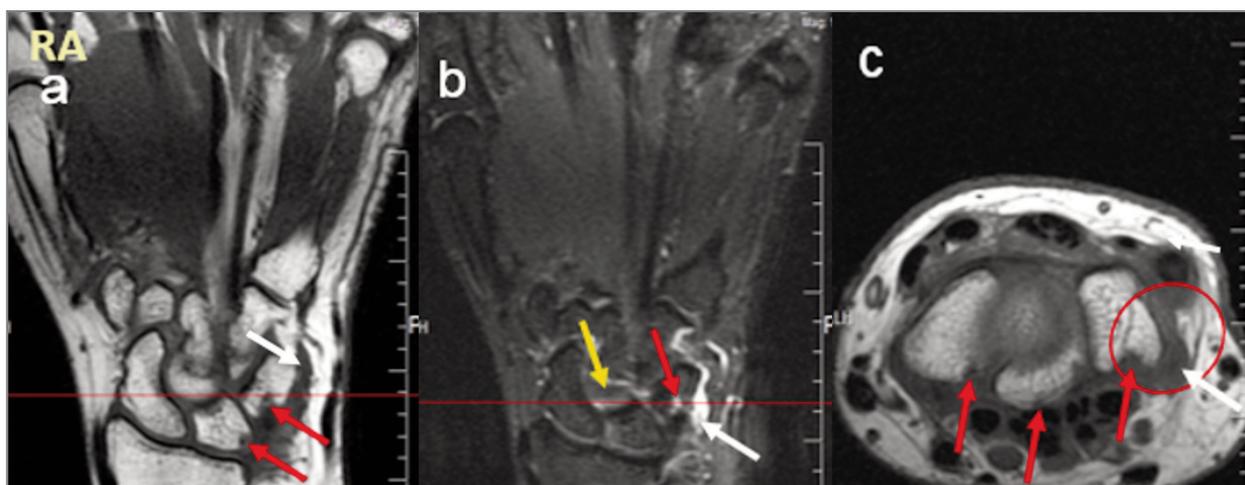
Hand-wrist MRI Coronal T1 and STIR in a rheumatoid arthritis (RA) patient. First Carpal line lesions in a 45 year-old woman. White arrows show synovitis; red arrow shows erosion; yellow arrows show bone marrow edema (osteitis). A) T1 sequence synovitis in triquetrum is seen hypointense (white arrow) and erosions are seen in the triquetrum, lunate and scaphoid bones edge with “no signal” (black signal), here seen hypointense in T1 due to joint effusion synovitis (red arrows). B) Synovitis on STIR sequence is seen hyperintense (bright white signal) in the triquetrum and prestyloid-triquetrum joint recess (white arrow); erosion in triquetrum is seen hyperintense with synovitis (red arrow); BME/osteitis is seen hyperintense in the capitate bone (yellow arrow). C) T1 axial slice, hypointense synovitis in prestyloid-triquetral joint recess (white arrow in red circle) and erosions with synovitis inside them, are seen hypointense in the triquetral, lunate and scaphoid bones (red arrow).
